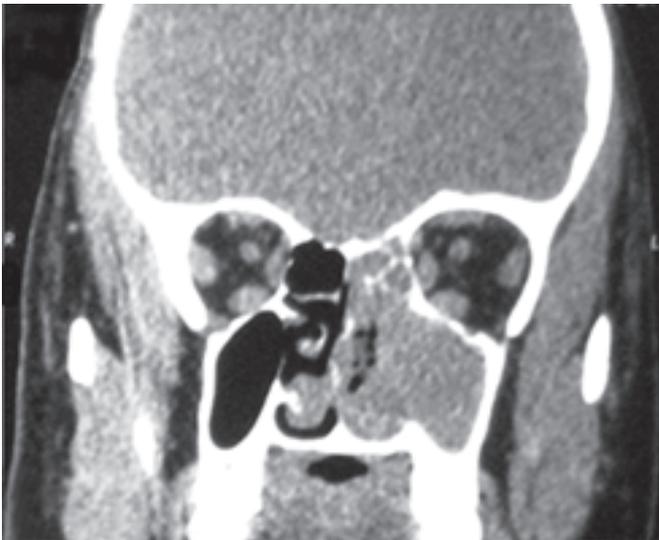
Contrast-enhanced computed tomography of paranasal sinuses (CT PNS), coronal view, showing a heterogeneous, moderately enhancing soft tissue lesion completely filling the left maxillary sinus causing erosion of the medial wall
